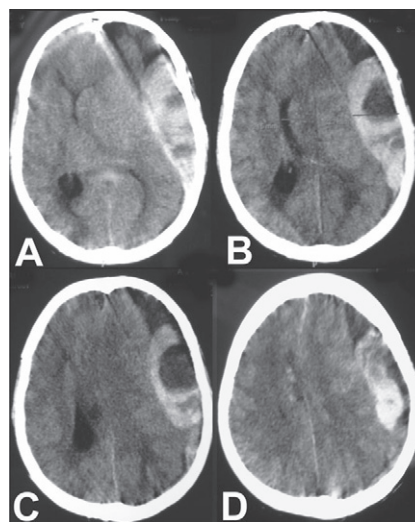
Computed tomography (CT) of the brain showing heterogeneous density of the lesion in the left fronto-temporo-parietal region with marked mass effect and midline shift (note the odd point that there was hypodense collection in the hyperdense collection contrary to classical hyperdense collection in the relative isodense or hypodense collection in cases of acute hemorrhage in chronic subdural hematoma)
